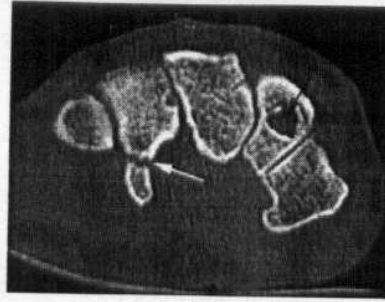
Axial CT scan demonstrating a fracture of the hook of the hamate (white arrow) that was not seen on plain radiography. An incidental intraosseous ganglion (black arrow) is present(Quoted from McAlinden, 2001).
